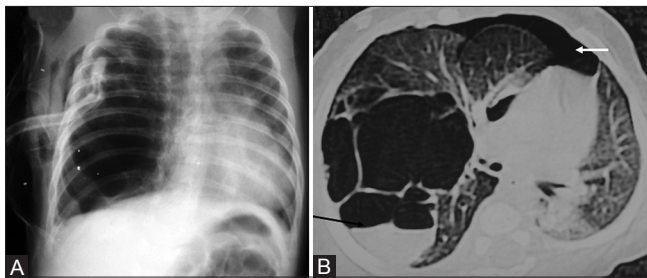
(A, B): (A) Chest radiograph shows cystic lucency involving the whole of the right lung field with chest tube insertion and subcutaneous emphysema. (B) Chest CT axial section with lung window shows multiple thin-walled cystic lesions showing air fluid level (black arrow) and pneumothorax (white arrow). Diagnosis was confirmed after surgery as type 1 CCAM
